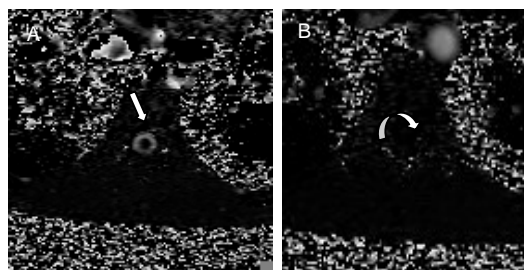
Cerebrospinal fluid (CSF) signals of normal adults using fast cine phase-contrast magnetic resonance imaging.
